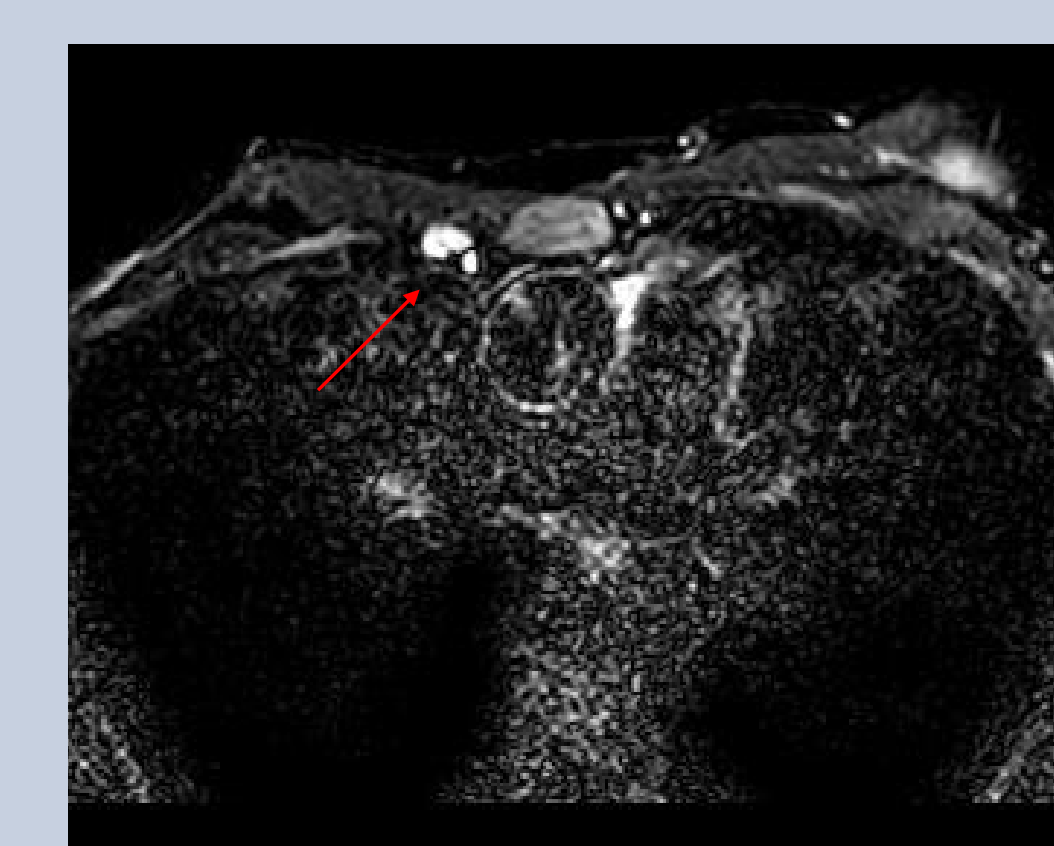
Water-suppressed MRI image demonstrating silicone within the right internal mammary lymph node.
